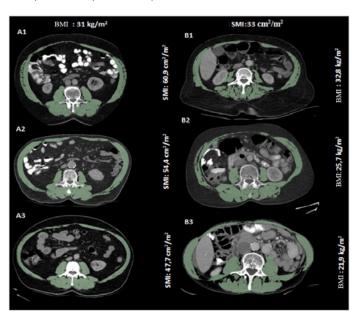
Skeletal muscle index measurements on CT sections through the L3 vertebra level. Left:Different SMI values of patients with the same BMI (31 kg/m²), respectively A1: 60,9 cm2 /m2, A2: 54,4 cm² / m^2 , A3: 47,7 cm²/m². Right: Different BMI values of patients with the same SMI (33 cm²/m²), respectively B1: 32,8 kg/m² B2:25,7 kg/m2, B3: 21,9 kg/m².
